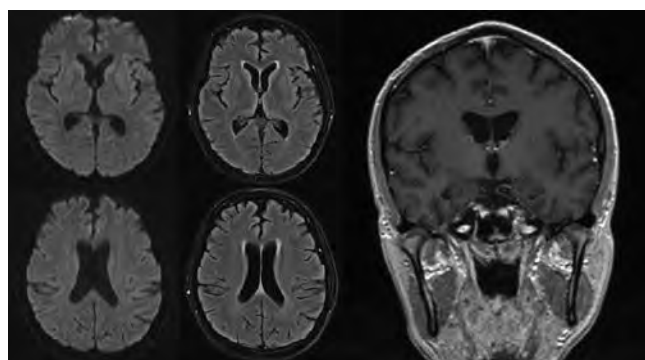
Magnetic resonance imaging of the brain showed no hyperintensities on diffusion weighted imaging (left), fluid-attenuated inversion recovery sequences (middle column), and no abnormal contrast enhancement in the meninges or temporal lobes (rightmost image).
